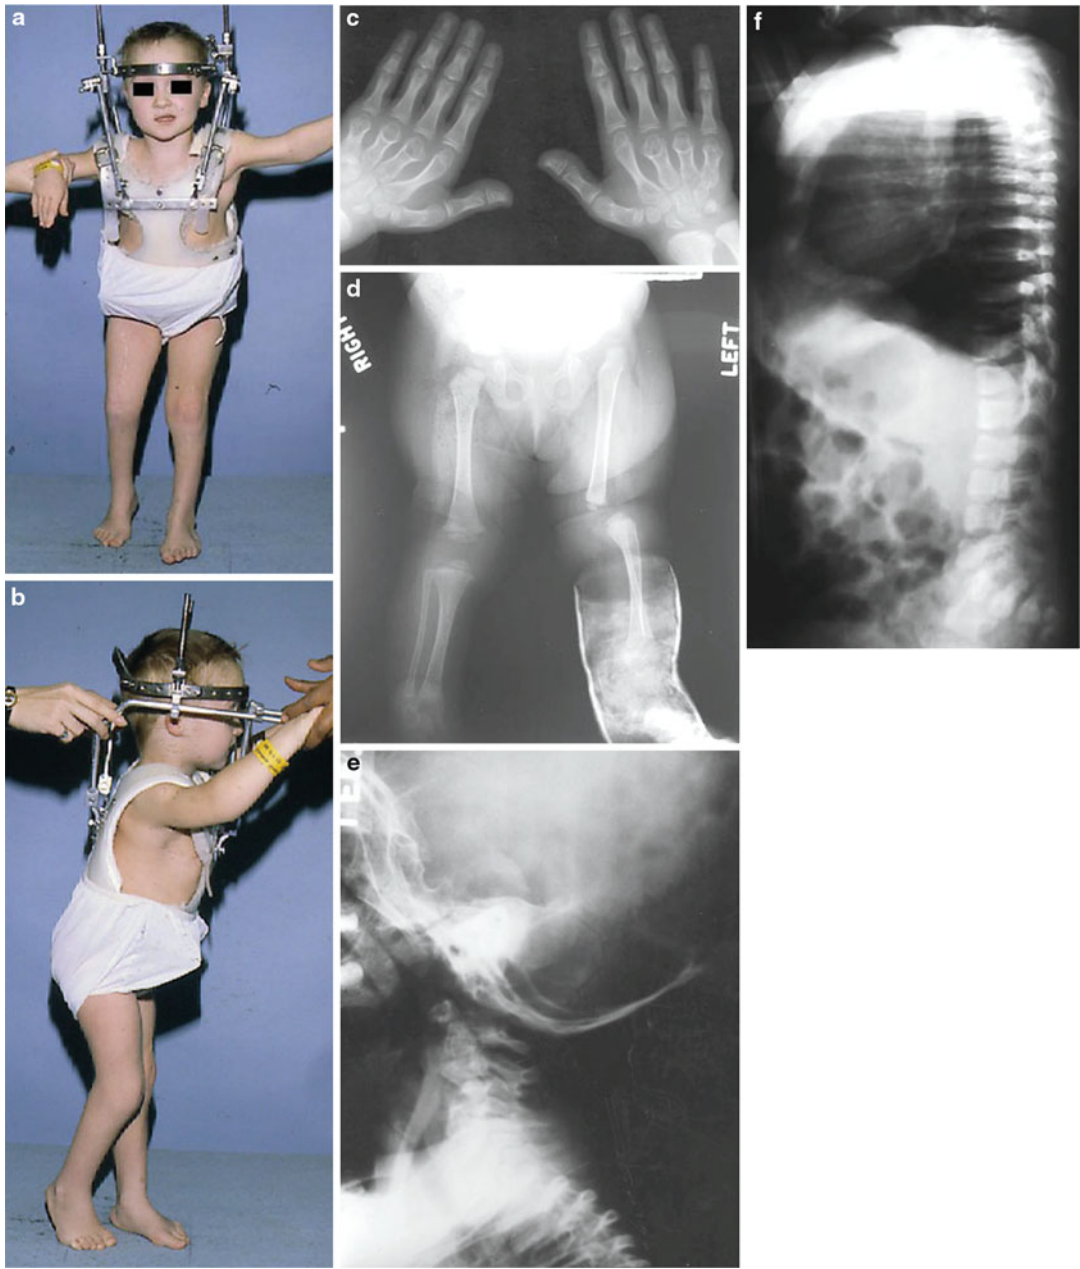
(a–f) A girl with Larsen syndrome (a, b) wearing orthosis, showing flat facies. Radiographs show an increased number of carpal bones (c), anterior and lateral dislocation of tibiae (d), hyperextended cervical vertebrae (e), and coronal clefting of the lumbar vertebrae (f)
